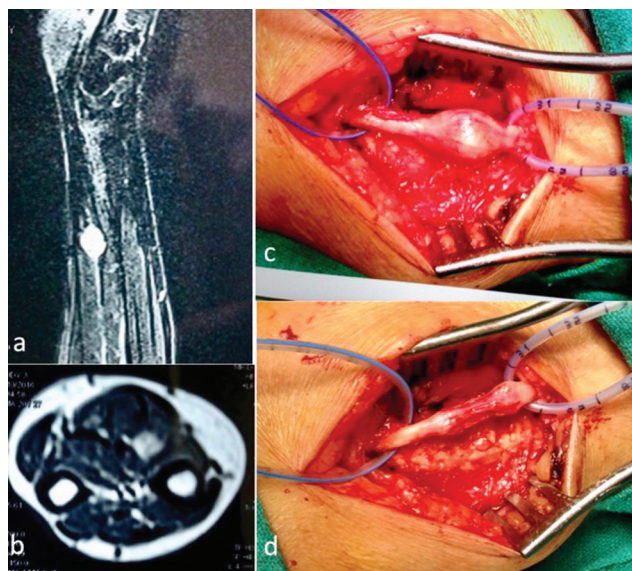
MRI examination of right forearm showed contrast-enhancing lesion deep to the flexor tendon of forearm (a, b). The tumor was arising from the median nerve in the right forearm, below the flexor tendon of forearm (c). The mass was encapsulated and removed totally (d).
